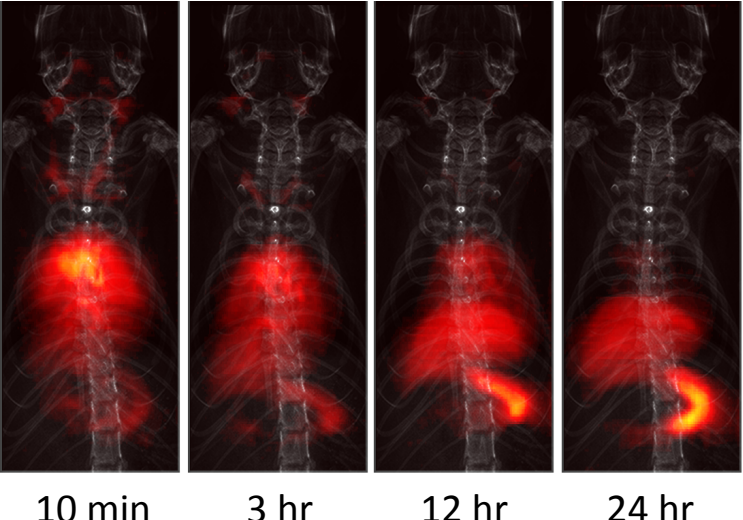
Short-term biodistribution MPI images overlaid on an X-ray projection for Ferucarbotran and LodeSpin (LS-008). Ferucarbotran is immediately cleared to the liver, while LodeSpin (LS-008) stays circulating in the blood with a half life of 4.2 hours.
